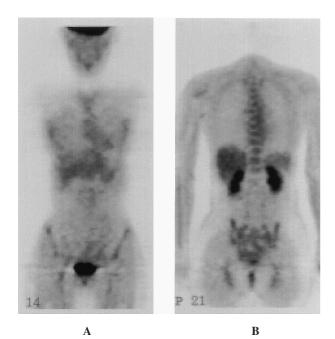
¹⁸F-FDG PET after chemotherapy revealed no abnormal uptake. (A) The abnormal uptake had disappeared in the region of the right ovary. (B) The abnormal uptake had disappeared in the region of the left ovary.
